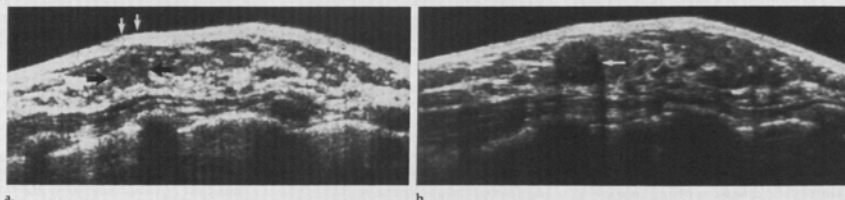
Longitudinal sonograms over a palpable mass in a 37-year-old woman. The 4-MHz scan (a) shows slight mass effect (white arrows) over the tumor (black arrows), which has the same echo texture as the adjacent fat. With the 7.5-MHz transducer (b), this 1.4-cm biopsy-proved fibroadenoma is clearly seen (arrows), because the internal echo texture is slightly less than that of the surrounding fat.
